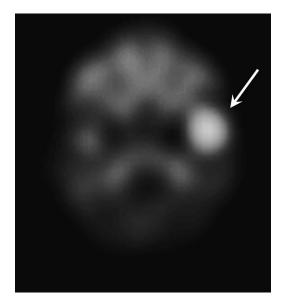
Axial view of SPECT bone scan. White arrow indicates increased uptake in the lesion in the left condyle.
